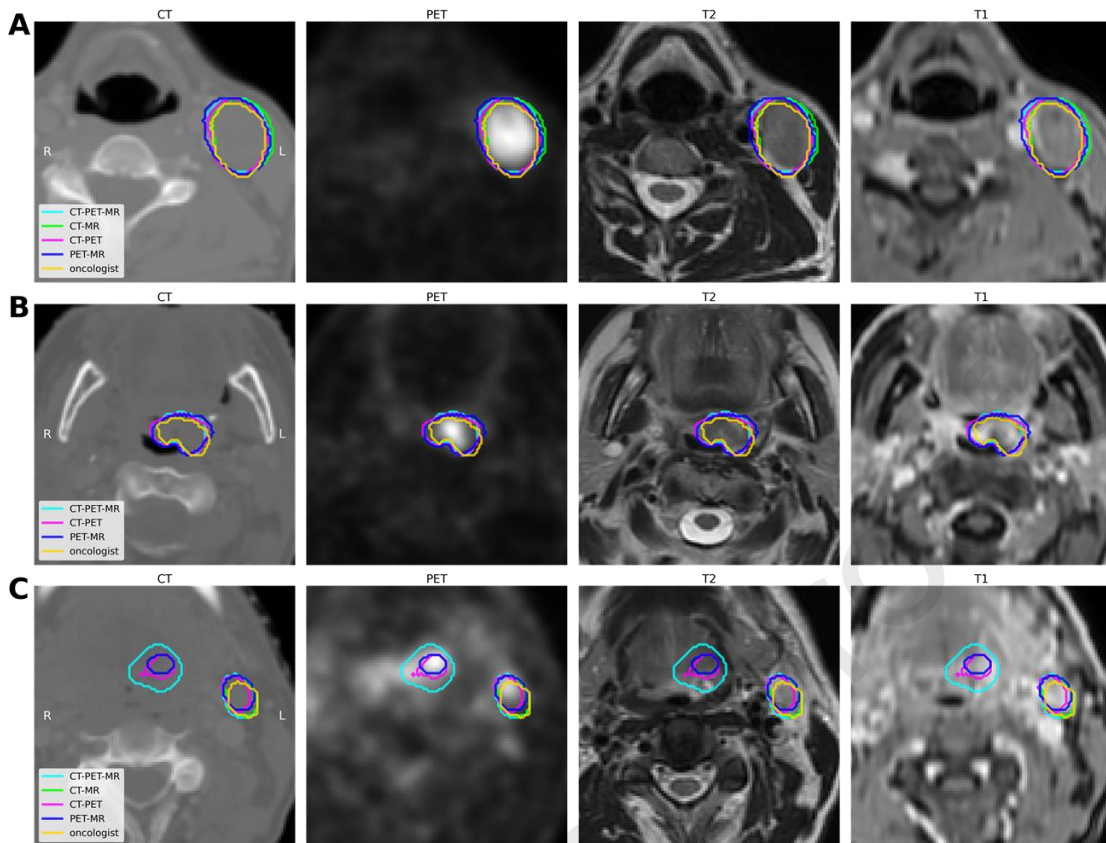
Three patient examples of GTV segmentation in oropharyngeal cancer using a 3D U-net network [34], based on different combinations of imaging modalities. Top row: A large lymph node target is well identified by all combinations of imaging modalities. Middle row: The primary target is only identified when PET is included, but not with CT-MR only. Bottom row: All imaging combinations with PET erroneously identify (part of) a primary target at the left side base of tongue, which is excluded by the CT-MR combination. Images courtesy of Jintao Ren, Jasper Nijkamp and Stine Korreman, Aarhus University.
